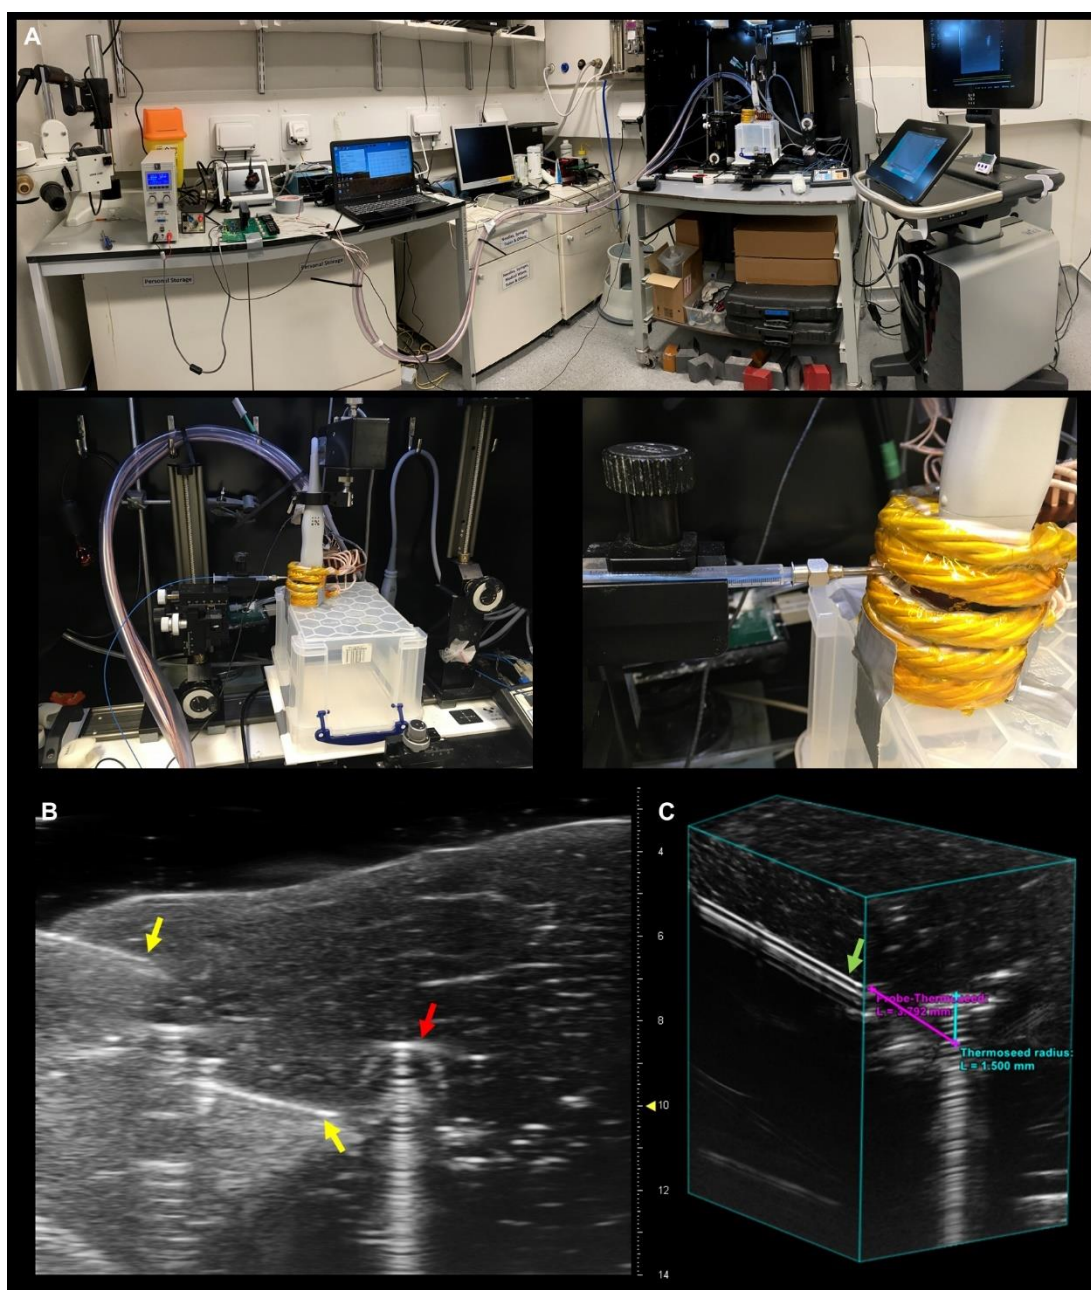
MACH system and ultrasound setup for heating in ex vivo liver tissue. A The MR-compatible MACH system was set up in the ultrasound lab, allowing the ex vivo liver tissue to be imaged whilst in the heating coil. B Ultrasound image of a 2 mm thermoseed (red arrows) in ex vivo liver tissue, with a needle inserted under ultrasound guidance (yellow arrows), to allow a fibre optic temperature probe to be placed a known distance from the thermoseed's surface. C 3D ultrasound images were used to measure the distance from the fibre optic probe (green arrow) to the thermoseed. Repetitions performed with the fibre optic probe at different distances from the thermoseed's surface allowed an understanding of the temperature distribution around the thermoseed to be formed.
